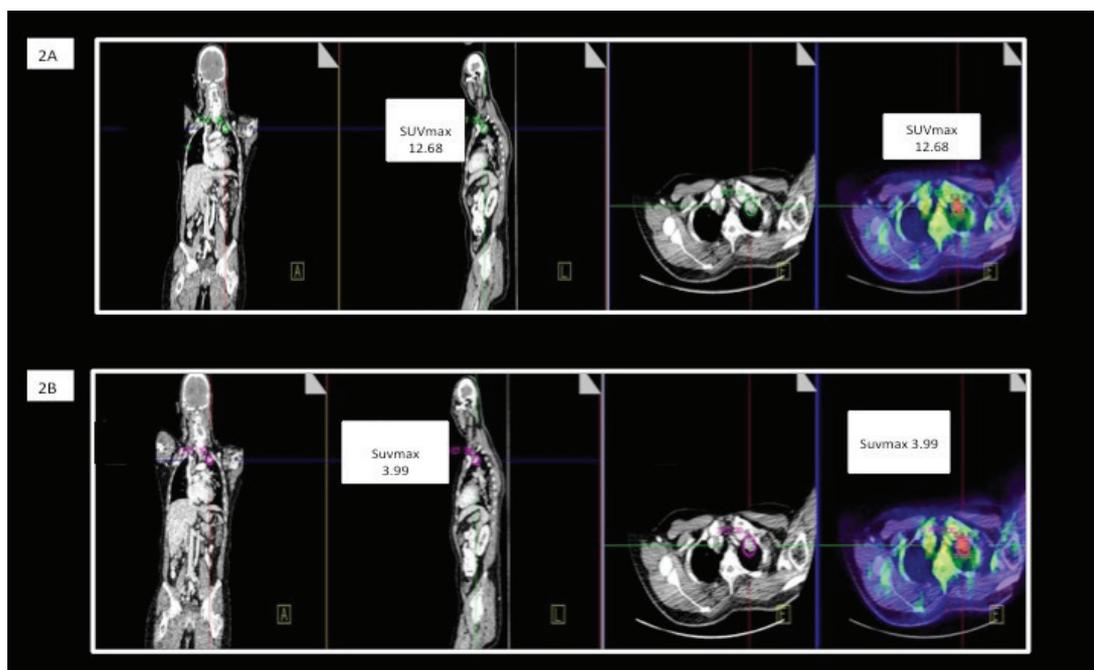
A 58-year old gentleman, diagnosed with inoperable NSCLC had been treated with 2nd line EGFR inhibitor therapy. (A): Initial PET/CT detected a left apical lung mass which showed avid FDG uptake, SUV_{max} 12.68g/mL. (B) Follow-up PET/Ct after several months of therapy detected reduction in SUV_{max} to 3.99g/mL, without a significant change in tumour size, demonstrating a partial metabolic response (PMR).
